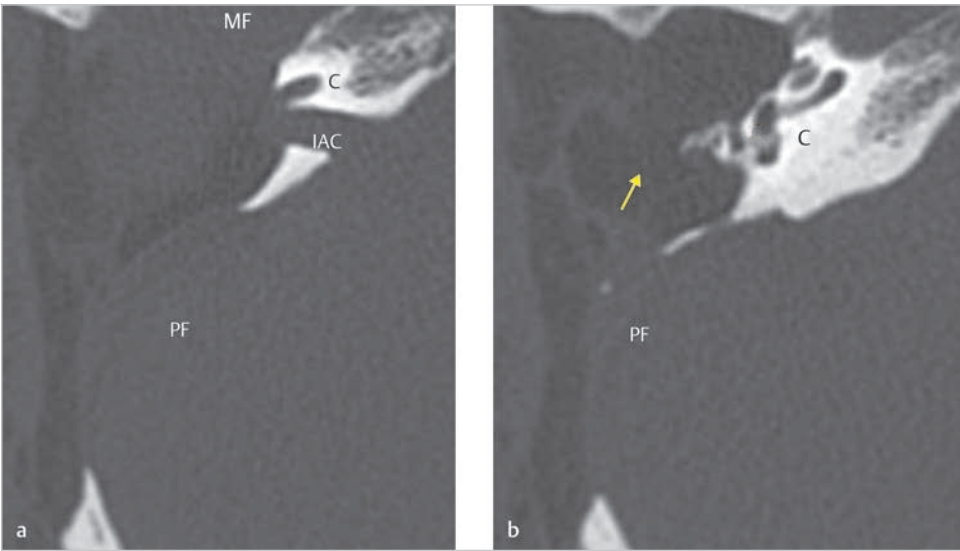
Postoperative axial CT on the left shows partially drilled cochlea and the internal auditory canal with wide exposure of both the middle and the posterior fossae dura. The facial nerve can be identified (*arrow*) in the more caudal slice (right). C, cochlea; IAC, internal auditory canal; MF, middle fossa; PF, posterior fossa.
